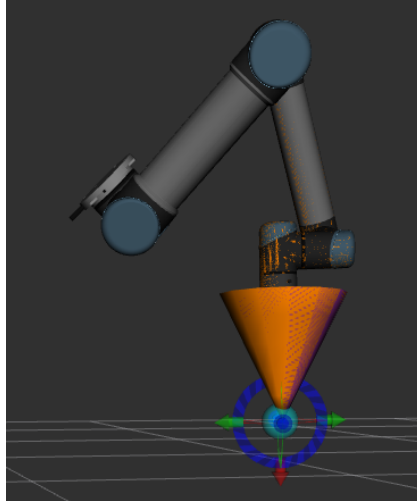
Rviz screenshot displaying the UR5 robot, including the conical obstacle attached to the end-effector to avoid collision with the ultrasound probe and camera.
